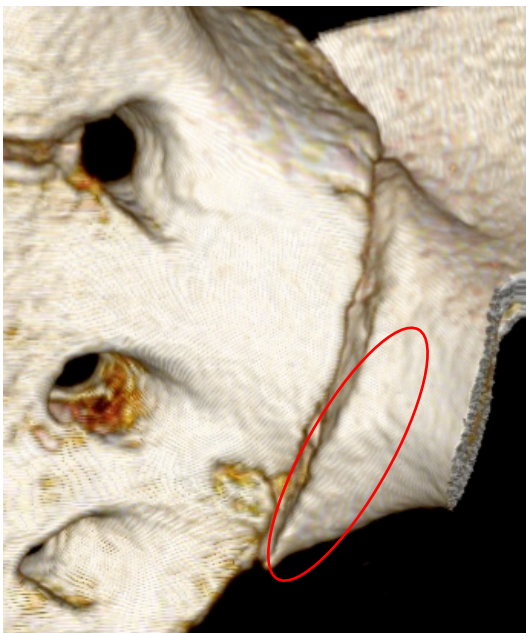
3D CT image of a grade 0 (left *os coxae*) Figure 6.3- 3D CT image of a grade 1 (right *os coxae*)
